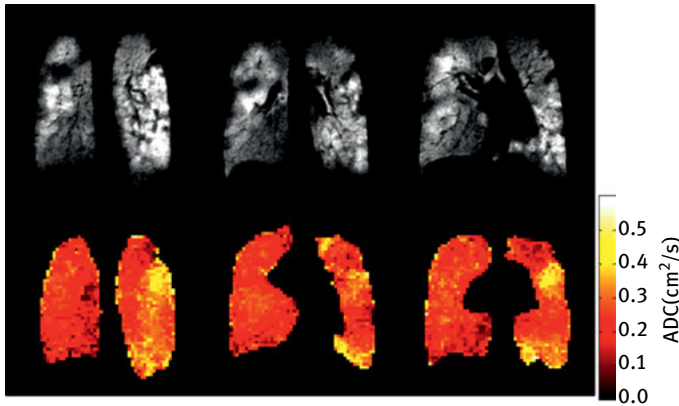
Hyperpolarized ^3He MR images of an 18-year-old CDH patient, treated with neonatal ECMO; (top row) ventilation-weighted images demonstrating multiple ventilation defects and (bottom row) maps of ^3He apparent diffusion coefficient (ADC) showing elevated ADC in the ipsilateral lung compared to the contralateral lung consistent with enlargement of mean dimensions of the confining lung micro-structure at the alveolar level. (Images provided by Helen Marshall and Jim Wild, POLARIS, Academic Radiology, University of Sheffield, UK).
